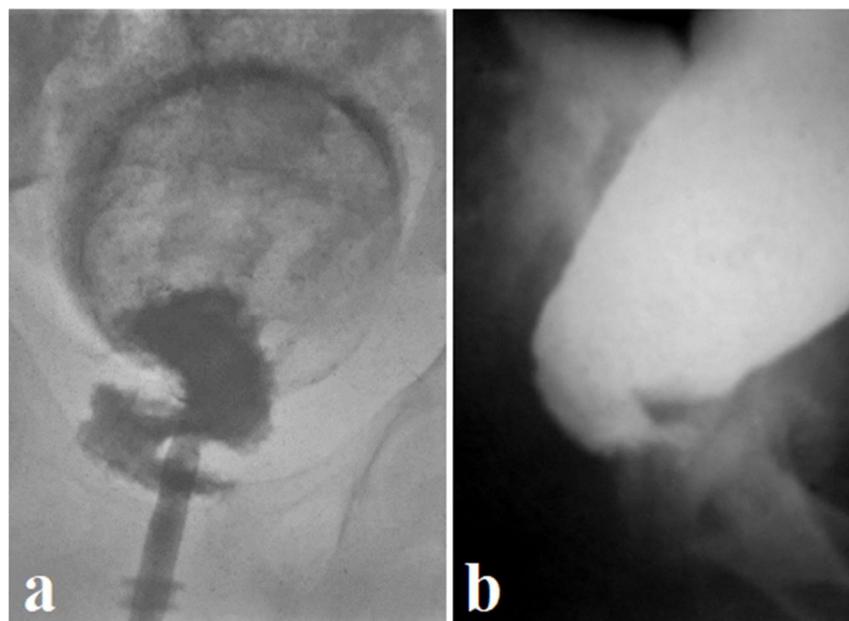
Frontal (a) and lateral (b) radiographs patients with HD.
